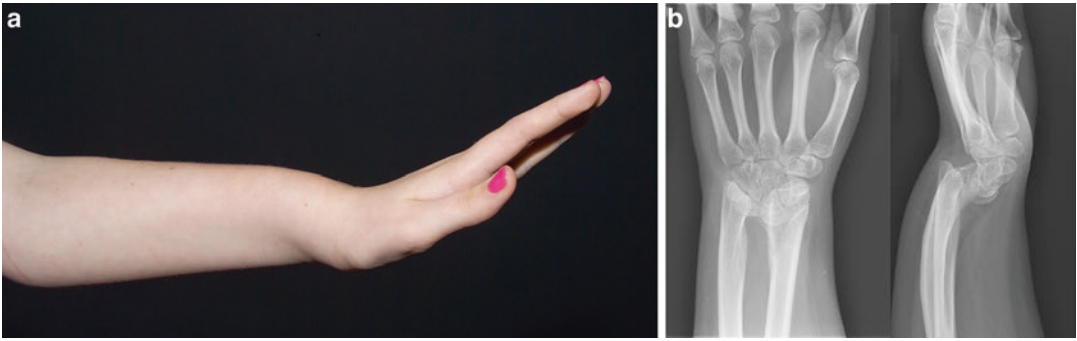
(a) Clinical photograph and (b) AP and lateral wrist radiographs of patient with Madelung deformity. (Copyright Shriners Hospitals for Children—Northern California)
